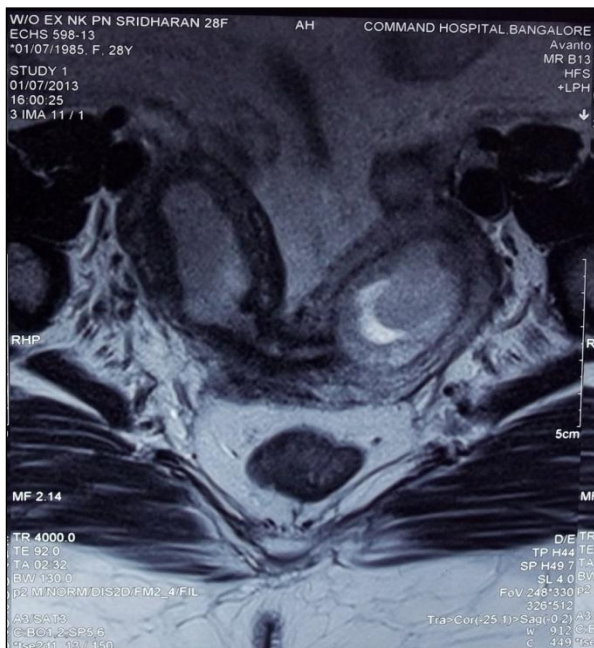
MRI image of pelvis showing Bicornuate uterus with intrauterine gestational sac in left horn.
